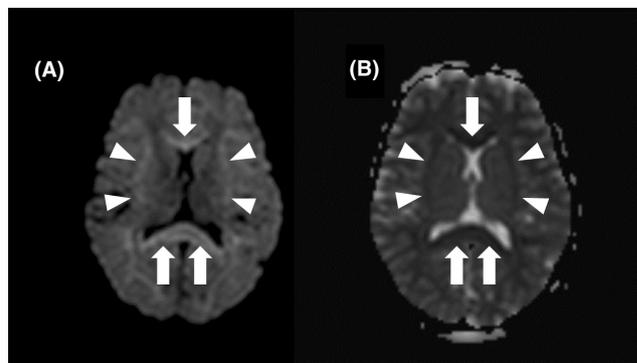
Brain MRI from the patient showing an acquired lesion of the corpus callosum (arrow) and hemispheric white matter (arrowhead), hyperintense on DWI (A), and hypointense on the ADC map (B). ADC, apparent diffusion coefficient; DWI, diffusion-weighted imaging; MRI, magnetic resonance imaging.
